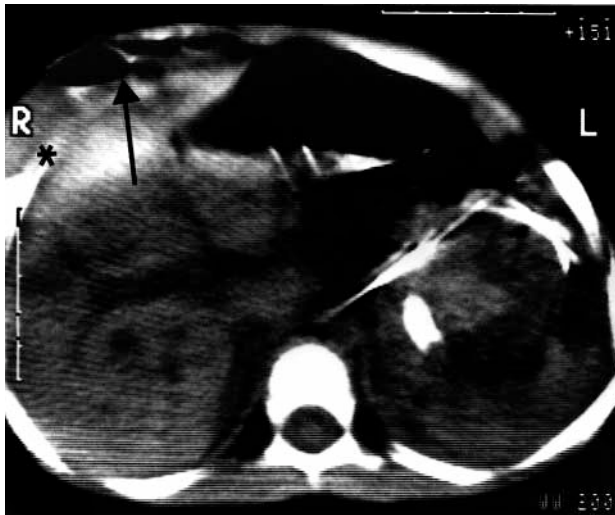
A thoracic CT showing protrusion of intestinal loops to the presternal and right lower thoracic region with intact diaphragm.
